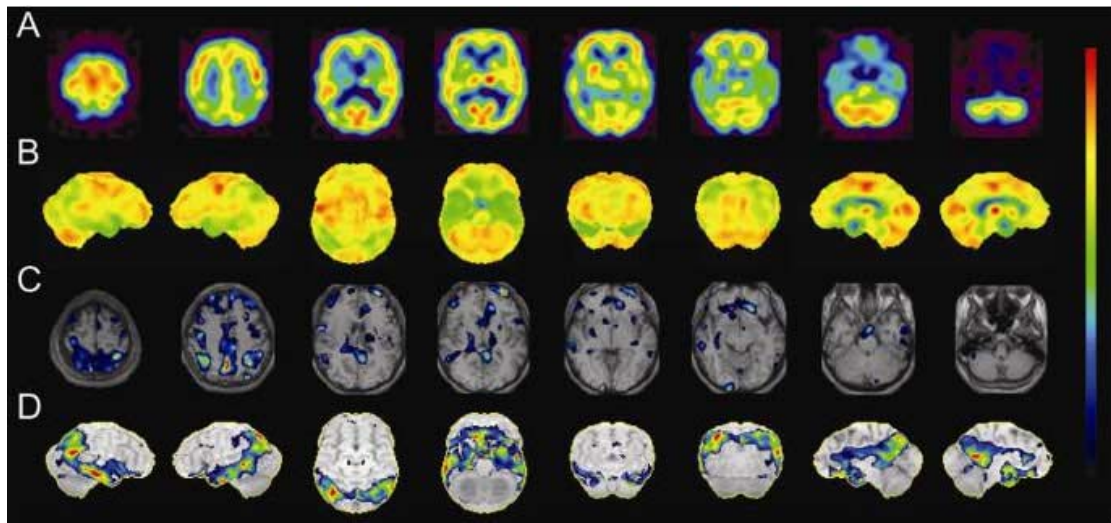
Representative SPECT images (A), 3DSSP images (B), Z-scores of SPECT images (C) and Z-scores of 3DSSP images (D) used for image interpretation experiment. Images in (B) and (D) are, from left to right, right lateral, left lateral, superior, inferior, anterior, posterior, right mid-sagittal, and left mid-sagittal views. Images in (C) and (D) were superimposed on template MR images.
